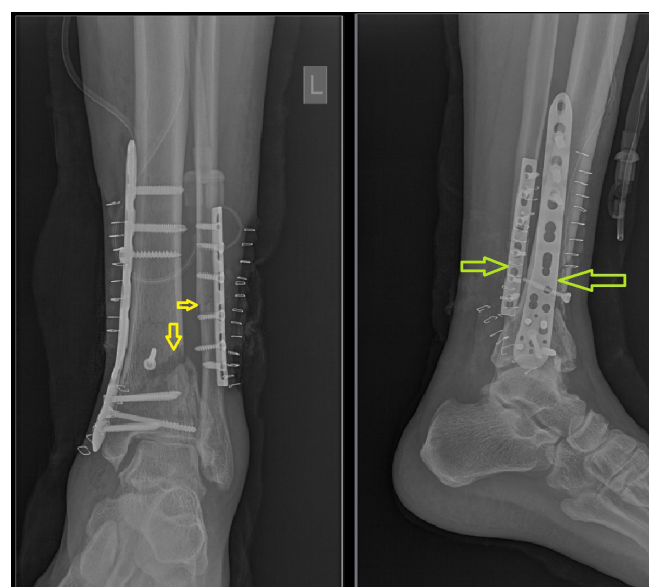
Anteroposterior and lateral radiographs of the left ankle demonstrating a comminuted fracture of the distal one-third shafts of the tibia and fibula, along with the postoperative status following open reduction and internal fixation (ORIF) of the distal fibula, showing satisfactory anatomical alignment and proper implant placement.
